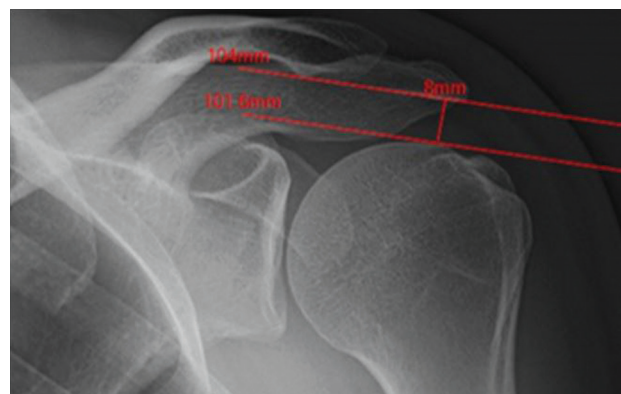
Determining the size of the subacromial space on the AP radiograph of the shoulder joint [19]
